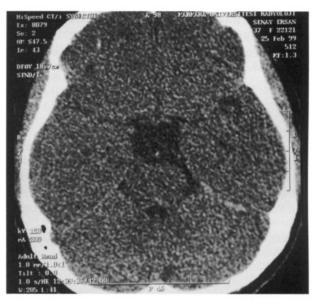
Axial CT shows a cystic lesion with density similar to that of CSF causing expansion of the suprasellar cistern.
